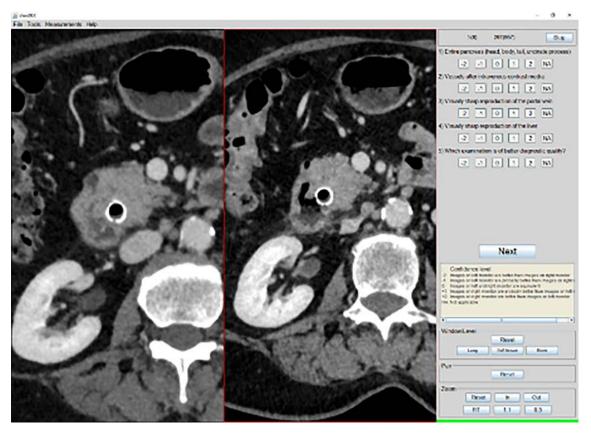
Comparison of EID-CT (right) and PDC-CT (left) in a a pancreatic cancer patient, analyzed regarding image quality parameters in ViewDex 3.0.
